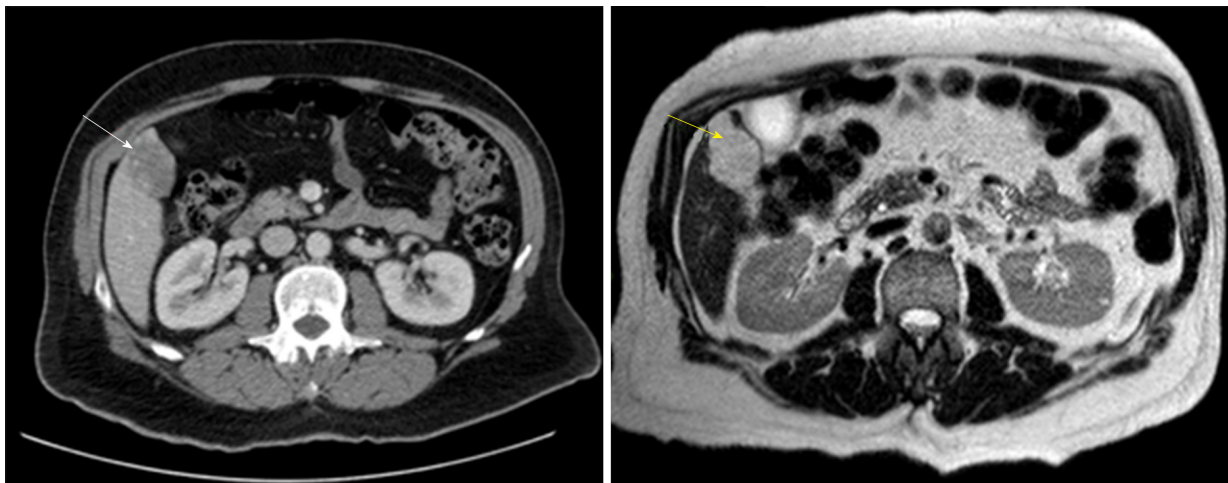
Computed tomography abdomen with contrast (white arrow) and magnetic resonance imaging T2-weighted scan (yellow arrow) with hepatic hemangioma 45 mm × 30 mm.
